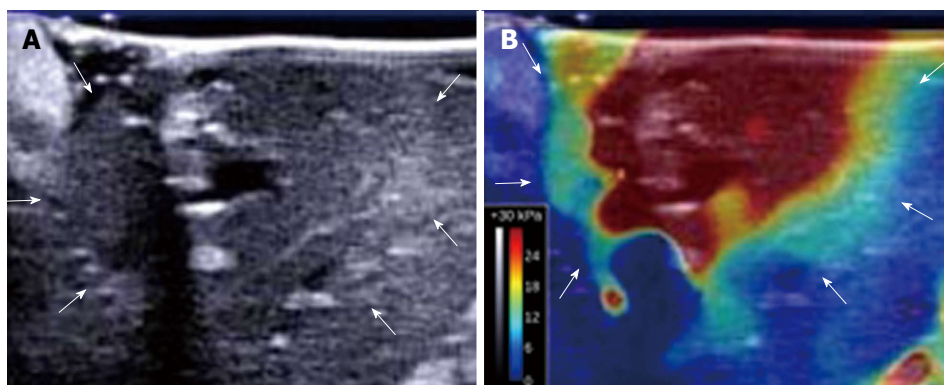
B-mode ultrasound image and shear-wave elastography image of a thermal lesion. A: B-mode ultrasound image of the liver obtained 15 min after ablation shows a poorly defined hypoechoic lesion with a hyperechoic rim (arrows); B: Corresponding shear-wave elastography image of the liver clearly delineates the ablated area (arrows).
